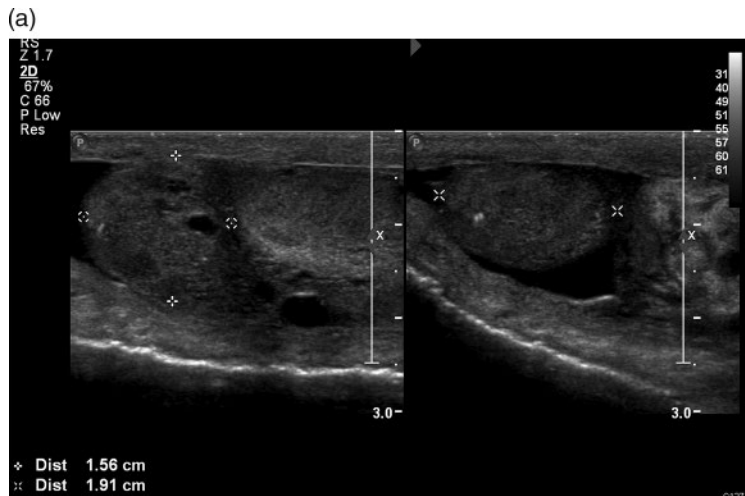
(a) Epididymitis with enlargement of the epididymal head (measured by callipers; left and right). (b) Orchitis demonstrating testicular oedema and increased flow to the testicle on power Doppler.
